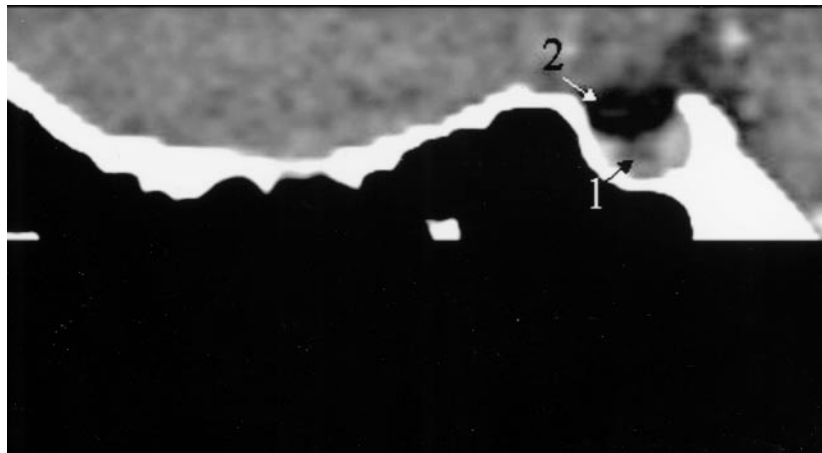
Sagittal CT view of the sella turcica in a patient with SSc. Arrow 1 shows microadenoma with posterior displacement of pituitary gland. Arrow 2 shows partially empty sella turcica.
